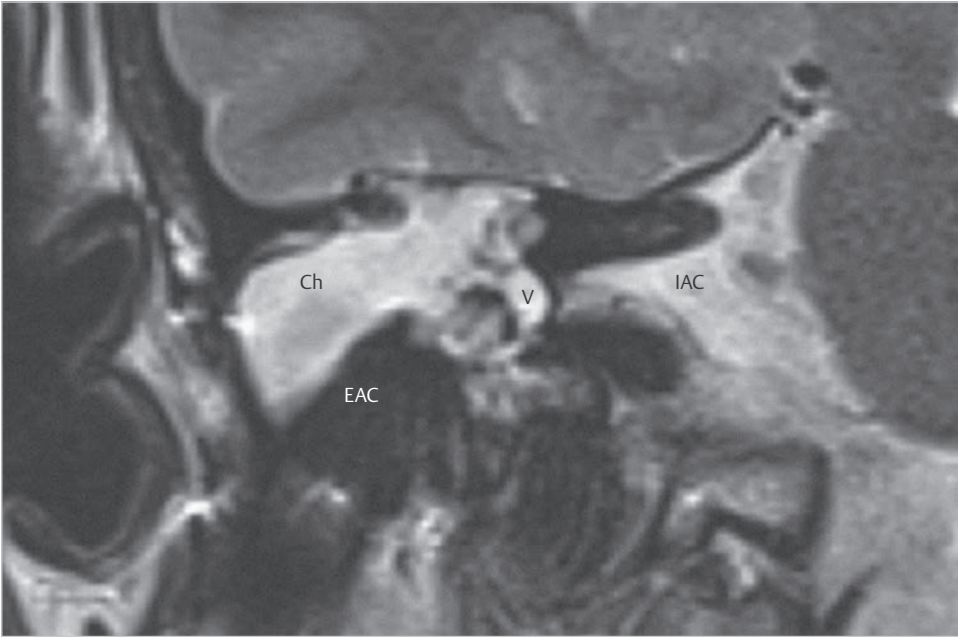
The coronal section of T2-weighted image shows high signal intensity filling the mastoid. Presence of fistulae is better recognized in CT due to higher space resolution. Ch, cholesteatoma; EAC, external auditory canal; IAC, internal auditory canal; V, vestibule.
